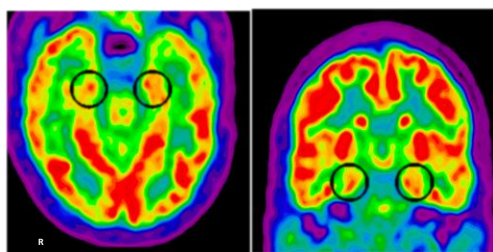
FDG-PET showing mild hypermetabolism of the amygdala bilaterally
